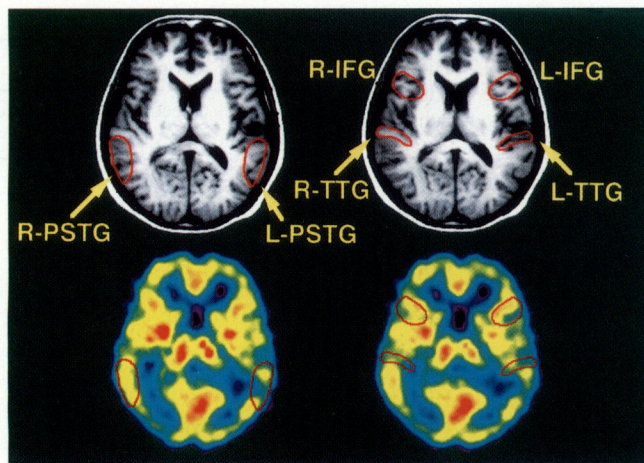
Regions of interest were placed with reference to the corresponding MRI after the co-registration of PET and MRI. The slice levels were 8 and 12 mm above the AC–PC plane. The same regions of interest were transferred to the PET image. In the patients without MRIs, regions of interest were placed on the PET images with reference to the atlas of Talairach and Tournoux (1988). R and L = right and left; IFG = inferior frontal gyrus; TTG = transverse temporal gyrus; PSTG = posterior superior temporal gyrus.
